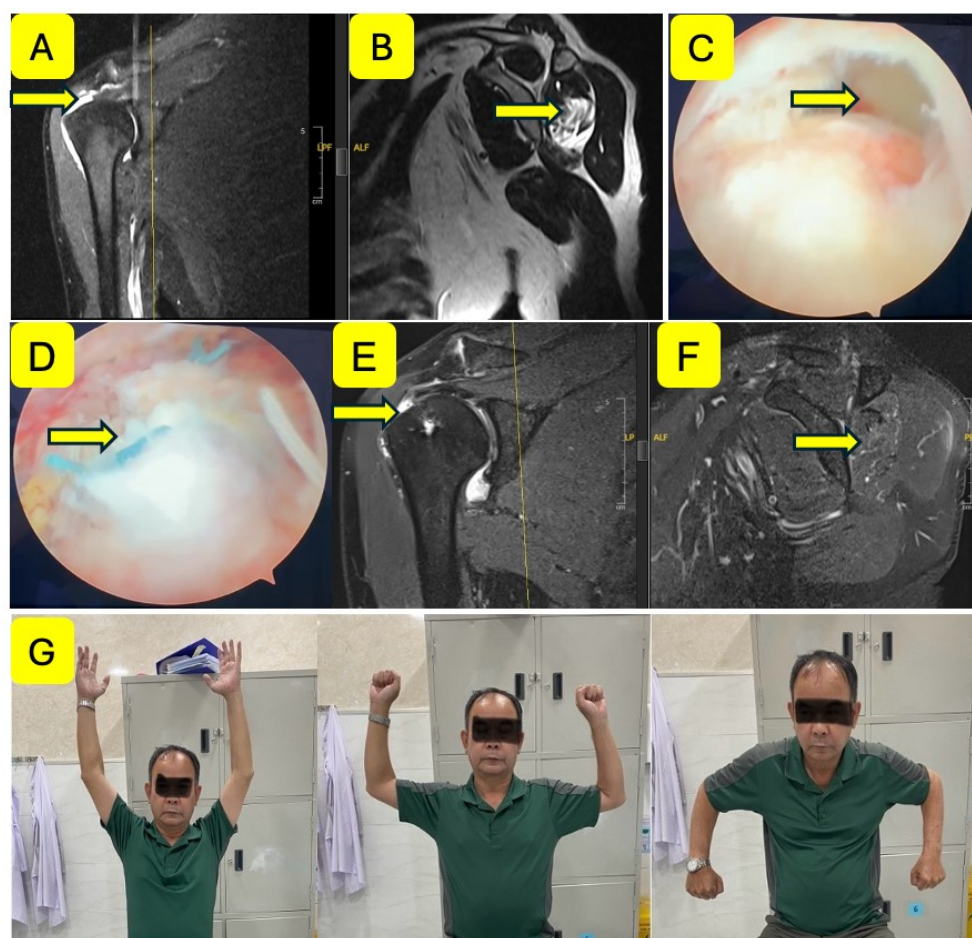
61 years old man, (A) MRI shows large full-thickness rotator cuff tear, right shoulder, (B) Goutallier grade 3 fatty degeneration, (C) 4 cm of crescent-shaped tear of the supraspinatus and infraspinatus tendons, (D) Single-row complete repair, (E) 39 months postoperative MRI shows less retracted retear, (F) 39 months postoperative MRI shows Goutallier grade 2 fatty degeneration, (G) Full ROM without pain at 39 months post operation.
